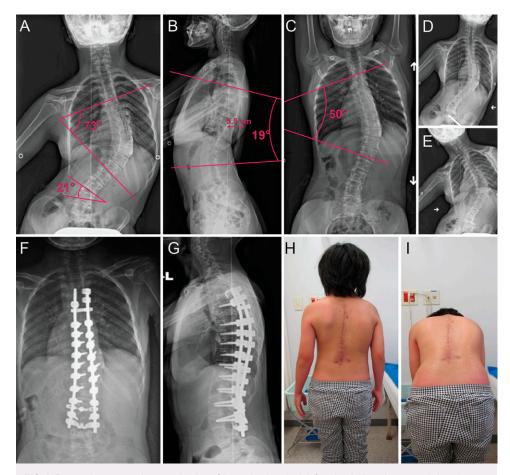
Pre- and postoperative examination of the patient's spinal deformity. A: Anterior coronal plane image revealed a right thoracic curve with a CA of 73° from T5 to L2 and an apical vertebra at T10–T11. The pelvic inclination was 21°. B: Sagittal plane image showed thoracic kyphosis of 19°, with a sagittal vertical axis of -2 cm and an apical RH size of 5.5 cm. C: Anterior coronal image under traction revealed a reduction in main thoracic CA from 73° to 50°, suggesting a relatively flexible spine. Anterior coronal image in right-leaning (D) and left-leaning (E) positions. Postoperative spinal deformity correction examination by coronal (F) and sagittal (G) radiographic images obtained after correction of the spinal deformity, which was accomplished using instrumented vertebral translation, direct vertebral rotation maneuver, and bone grafting of autologous bone graft obtained by decortication of the lamina combined with hydroxyapatite granules to mediate spinal segment fusion. The main thoracic curve with a CA of 73° before correction improved to a CA of 12°. The coronal plane balance improved. Visual examination in standing (H) and forward-bending (I) positions. RH prominence improved from 5.5 cm to 1 cm.
